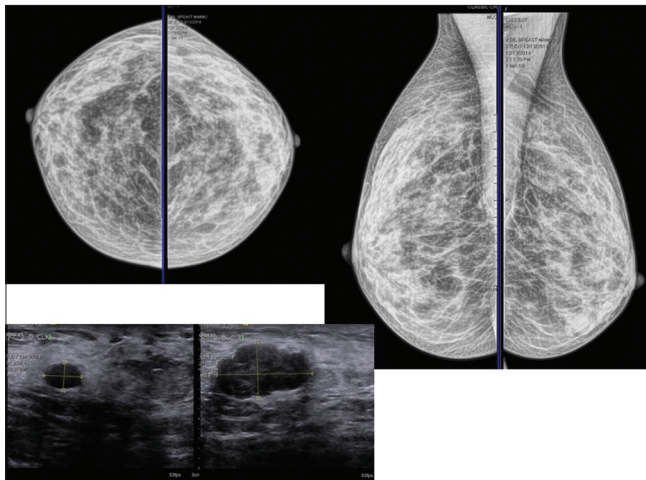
Mammography occult sols, sonography showed sols in both breast parenchyma, likely to be benign, presumed fibroadenomas
